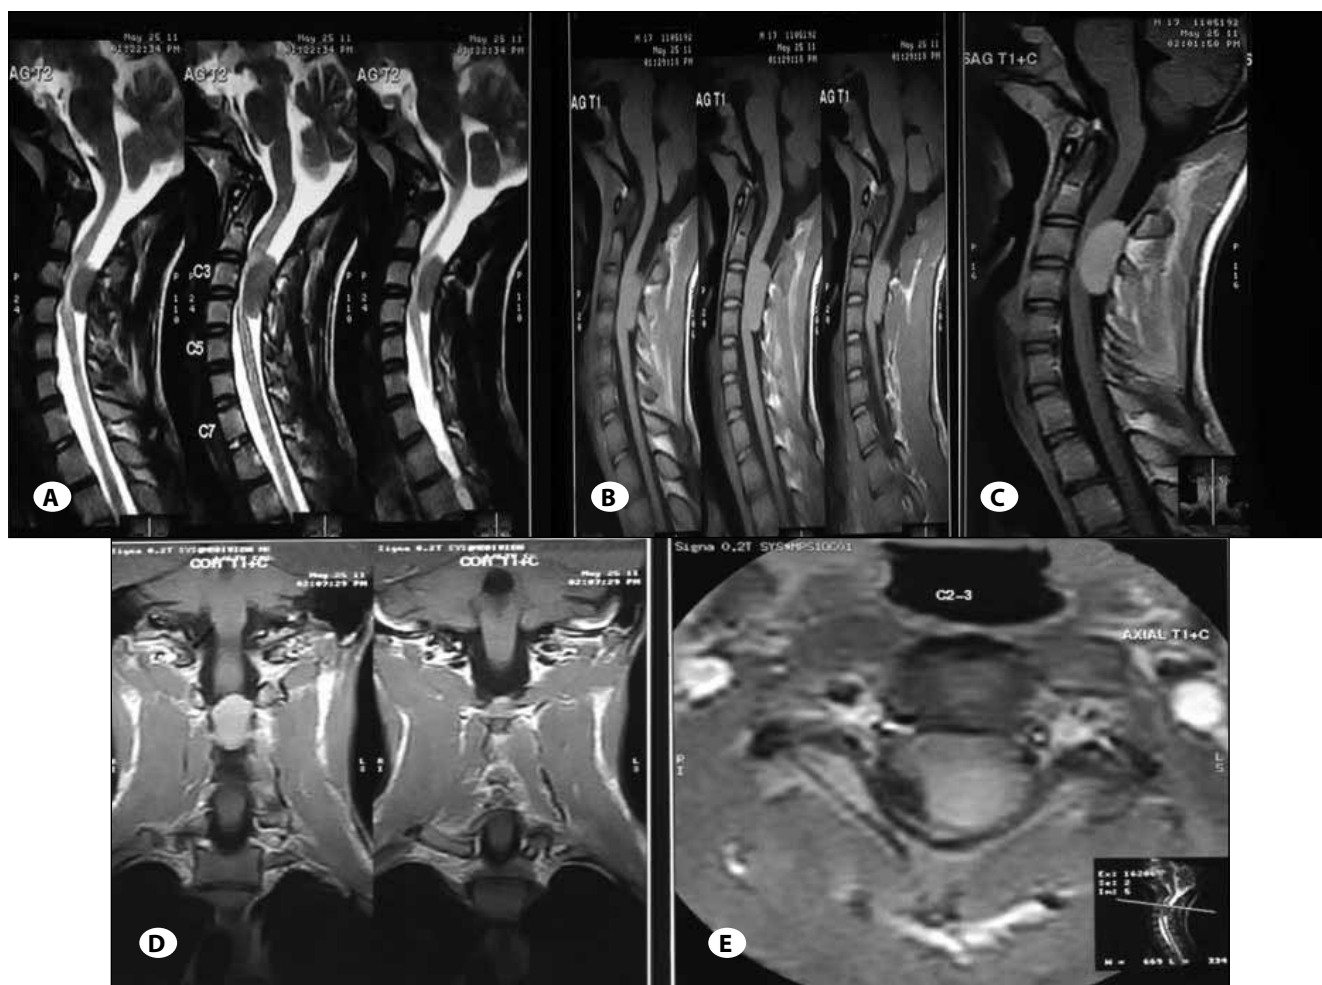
Magnetic Resonance Imaging (MRI) of Cervical Spine: A) SAG: T2W: Hypointense, ventrally located. B) MRI: SAG: T1W-isointense. C) MRI-Contrast-SAG-enhancing mass. D) MRI: Contrast: CORONAL: Centrally located. E) MRI: Contrast: AXIAL: Enhancing mass pushing cord anteriorly.
